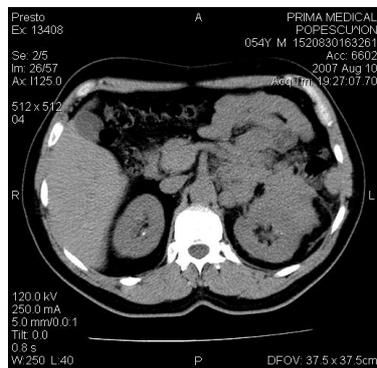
CT scan of the left retroperitoneal tumor.
